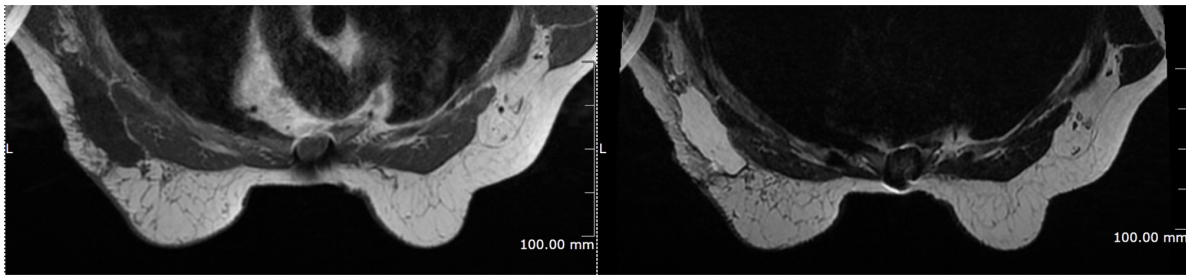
Bilateral breast magnetic resonance imaging. No breast lesion was identified.
